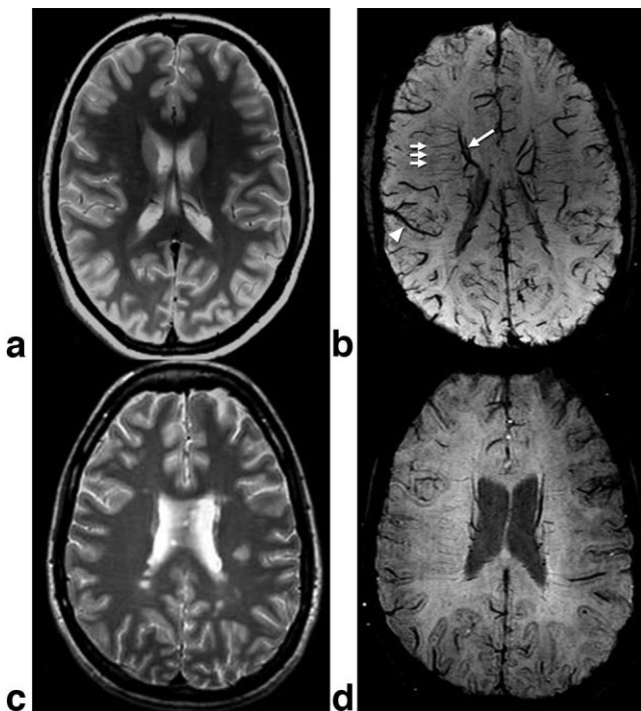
a–d: Conventional T2-weighted and SWI mIP images in a normal control (A,B) and in a patient with MS (C,D) demonstrate significantly reduced susceptibility contrast of venous blood on SWI processed mIP image in the patient as compared to the healthy control. Note that at the periventricular level, both small (e.g., medullary veins, indicated by small arrows) and large (e.g., longitudinal caudate vein of Schlesinger, indicated by long arrow) collecting veins, as well as cortical veins (arrowhead), are clearly delineated in the control participant, as opposed to their decreased visibility on SWI venograms in the patient with MS.
